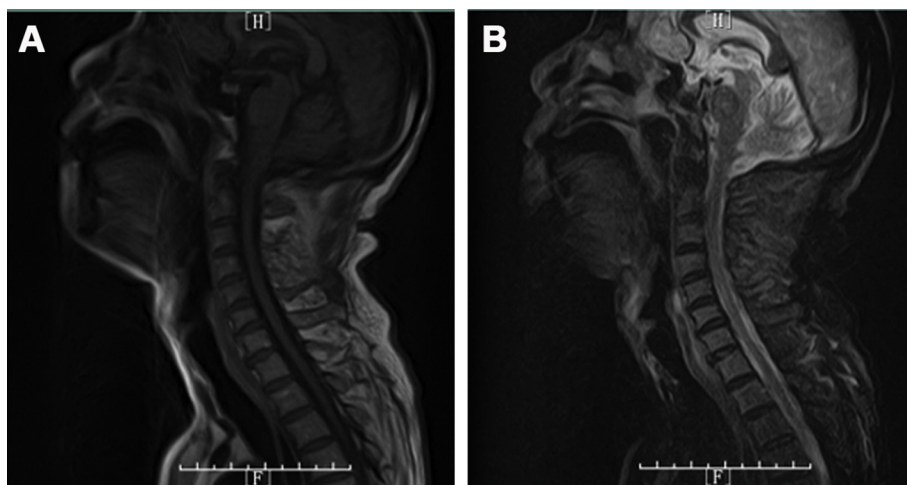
Cervical MRI: no obvious cervical spinal cord lesions. T1-weighted (A) and T2-weighted (B) MRI images of cervical showed degenerate and bulging of disk between C3 and C4, C4 and C5, as well as C5 and C6, but no obvious cervical spinal cord lesions.
